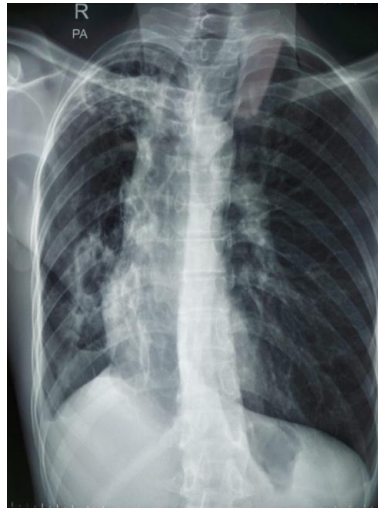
Posteroanterior projection thoracic X-ray examination results. There is a patchy infiltrate at the right pulmonary apex, tracheal deviation to the right, and a raised right diaphragm.
